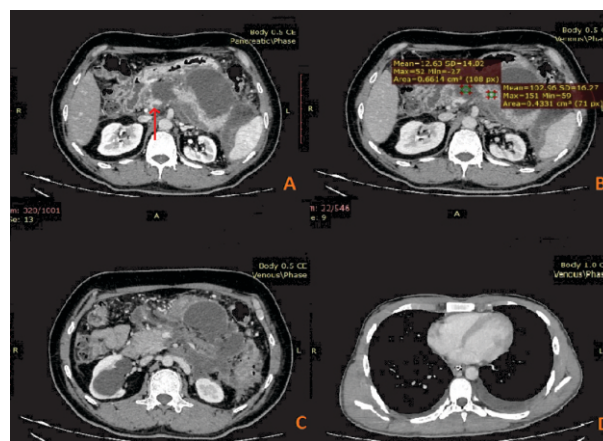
Axial CT sections in another patient show non enhancing areas in pancreas in a patient with necrotizing pancreatitis show A) thrombosis in portal vein B) non enhancing pancreatic parenchyma having density of less than 30 HU
